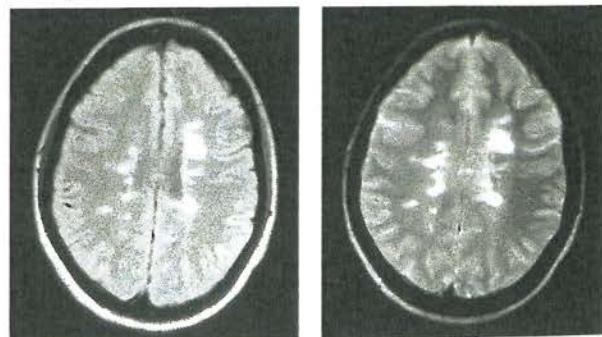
Axial MRI scan showing periventricular plaques of demyelination. Left: T1-weighted; right: T2-weighted
